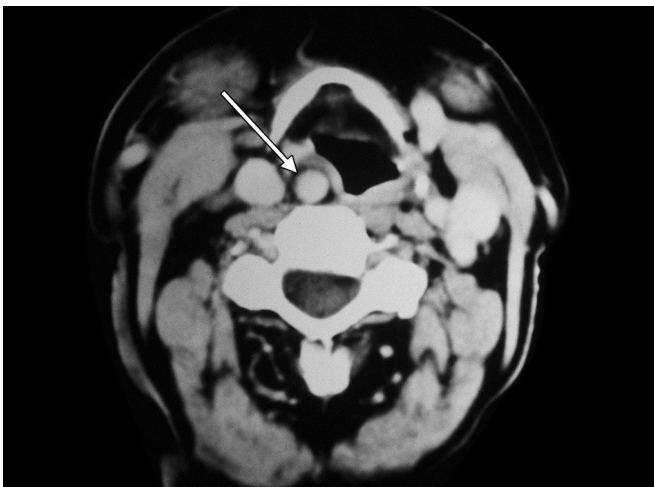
Contrast enhanced CT scan demonstrating medialized right internal carotid artery (white arrow) in a child with velocardiofacial syndrome.
